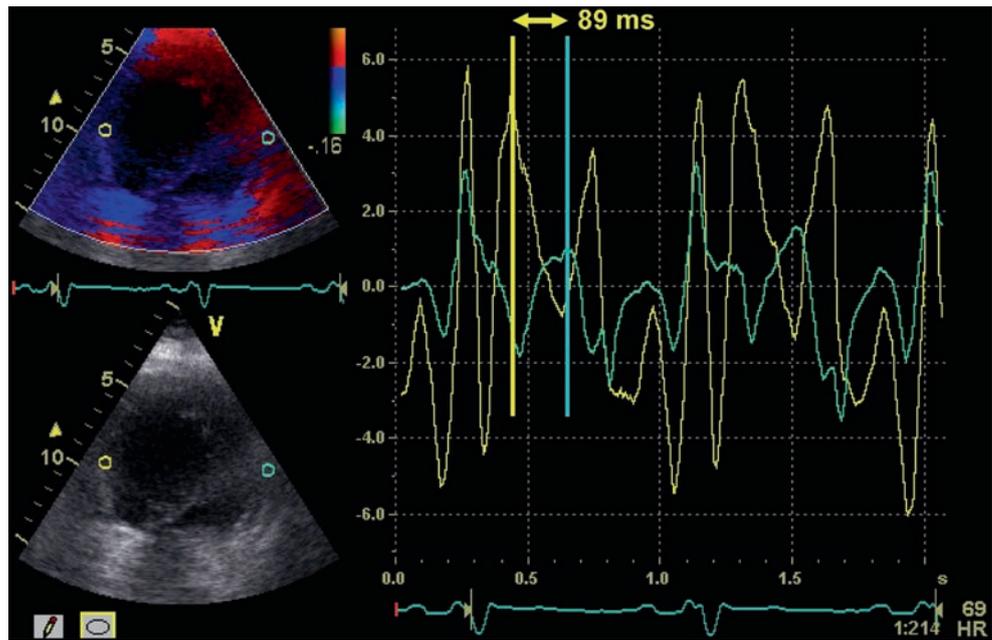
Intra-ventricular dyssynchrony assessment by measuring the time difference between the peak myocardial systolic velocities of the septal (yellow) and lateral (green) wall on colour-coded tissue Doppler images; in this patient the LV dyssynchrony is 89 ms. A time difference exceeding 65 ms (significant intra-ventricular dyssynchrony) is predictive for CRT response
